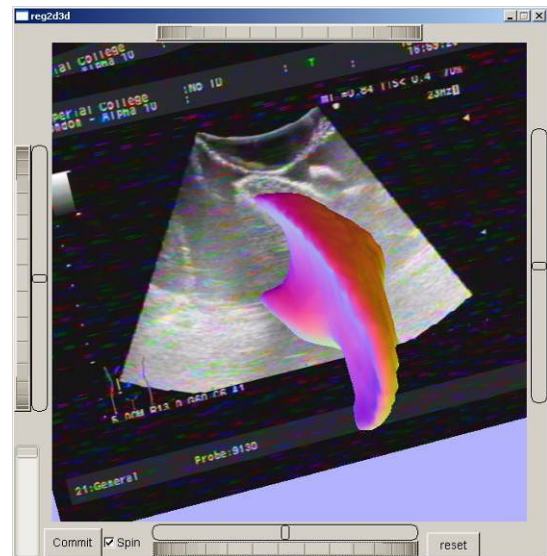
An ultrasound scan aligned to the model of the liver in an in-house surgical navigation tool.
